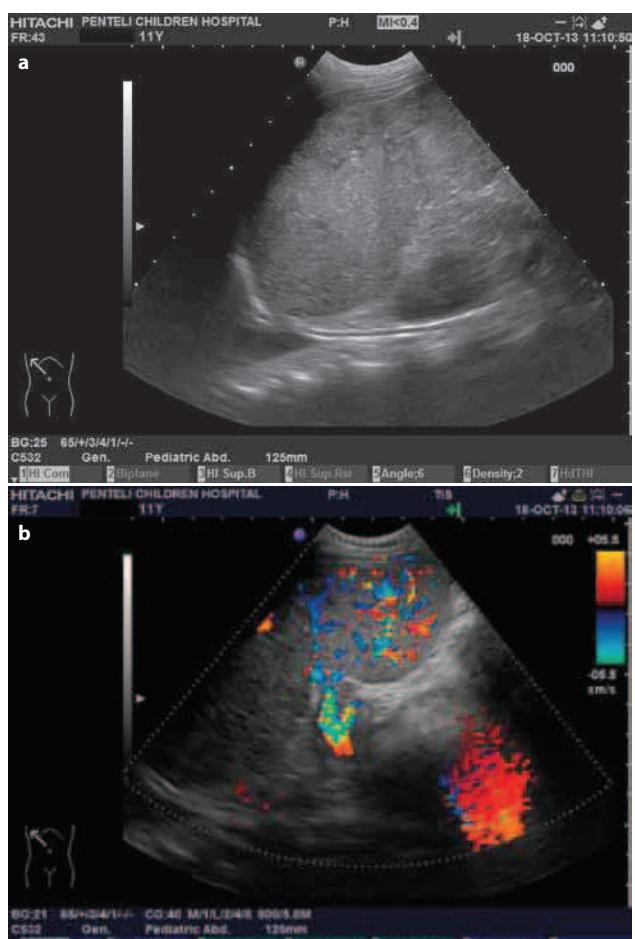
(a) Gray scale oblique view of left upper quadrant: Focal relatively hypoechoic lesions in splenic parenchyma, consistent with lacerations. (b) Same view with color Doppler, reveals no perfusion of upper portion of spleen.
